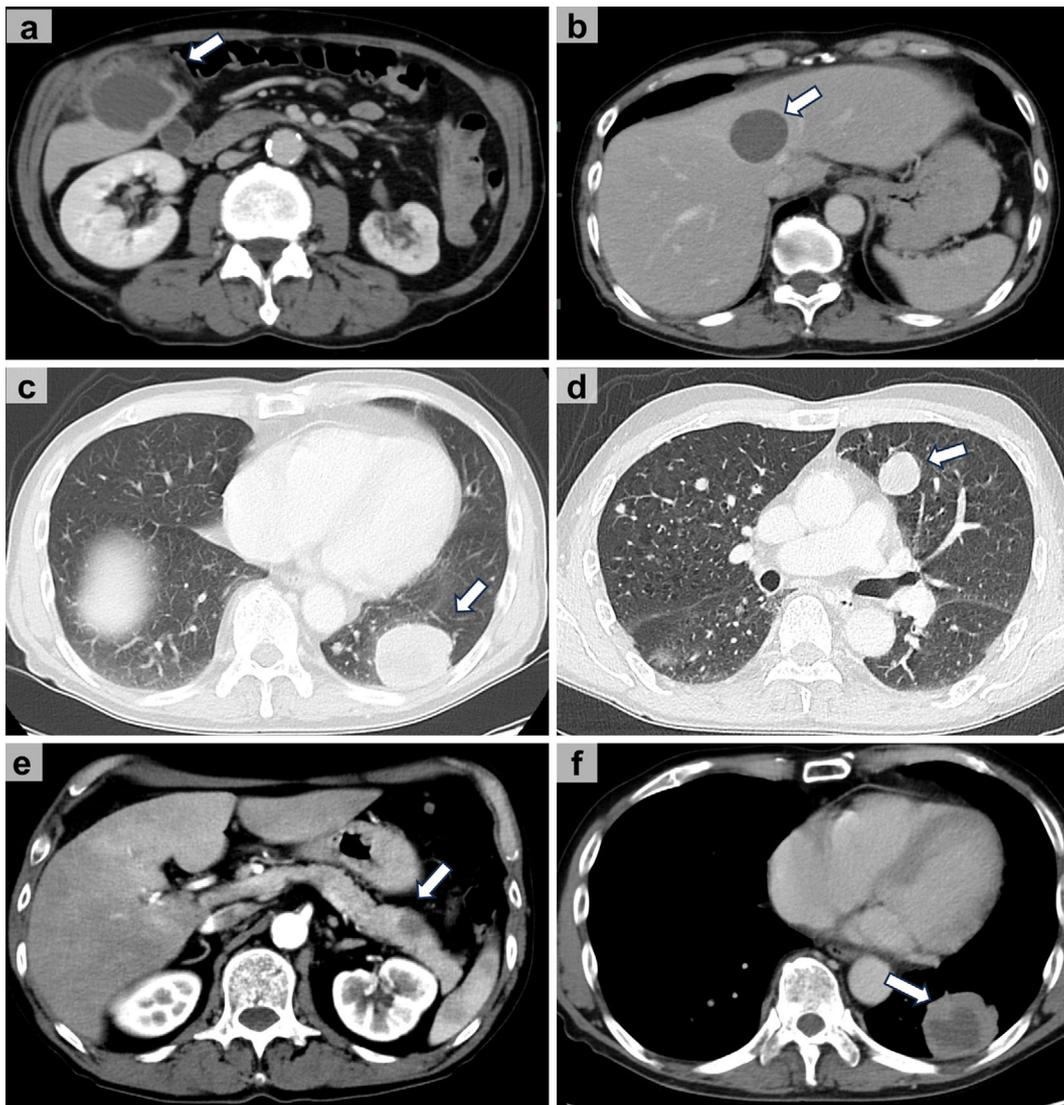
Computed tomography findings at initial presentation. (a) Rupture of a liver tumor measuring 45 mm in the S5/S6 region (white arrow). (b) Another liver mass (white arrow). (c-d) Multiple masses in both lungs (white arrow). (e) A mass in the tail of the pancreas (white arrow). (f) A lung lesion exhibiting necrotic changes, indicative of the aggressive nature of the tumor (white arrow).
